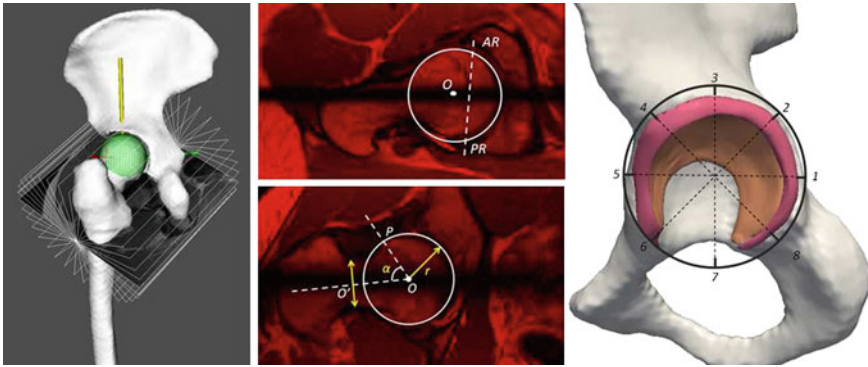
Standard morphological measurement based on subject-specific 3D models and MRI data. Devision of the acetabulum in eight sectors for radiological analysis
